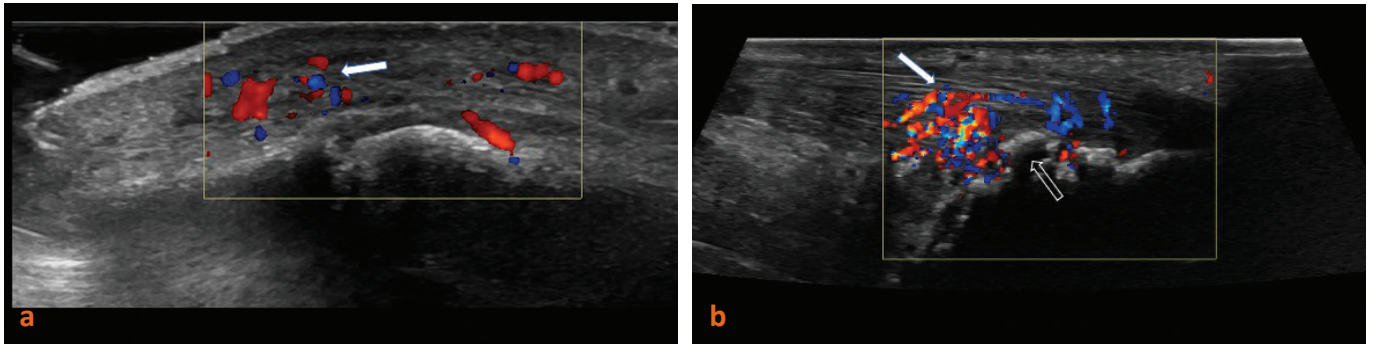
US findings in peripheral SpA. (a) Longitudinal scan of the index finger: soft tissue swelling, positive Doppler signal – dactylitis (white arrow) in a patient with Psoriatic Arthritis. (b) Longitudinal scan of the Achilles tendon enthesis: enthesitis with positive Doppler signal (white arrow) osteoproliferation and bone erosions (void arrow) in a patient with SpA.
